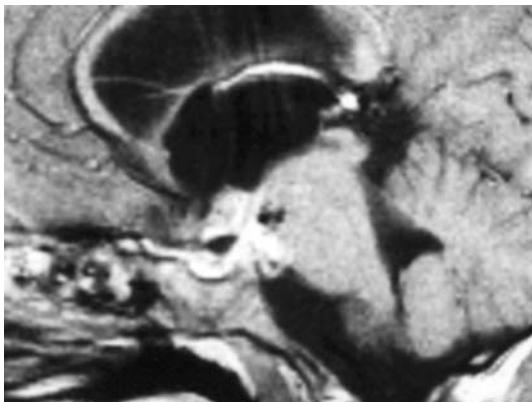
Same patient. Postoperative MRI after contrast injection, showing on a sagittal view the persistence of a nonnegligible volume of CP
